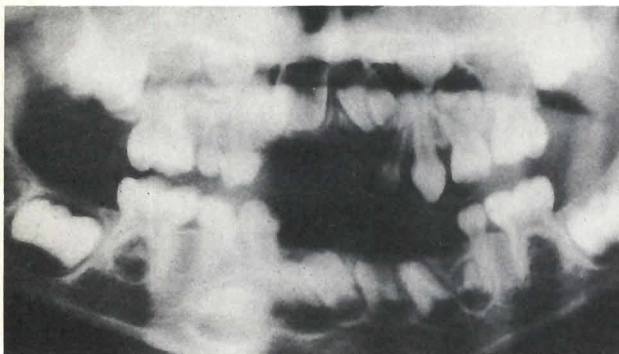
Orthopantomogram at the age of four years. Note that all the permanent buds are present.
